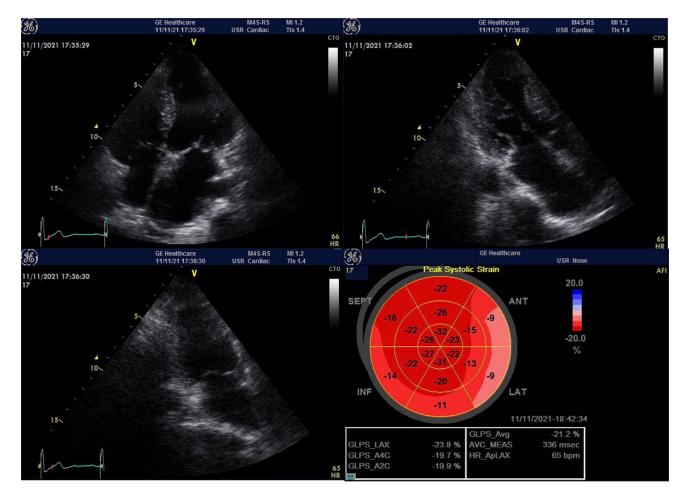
Speckle-tracking strain of the left ventricle before valve operation. Numbers shown on the picture represent segmental and global systolic strain values of different Echocardiographic View.
